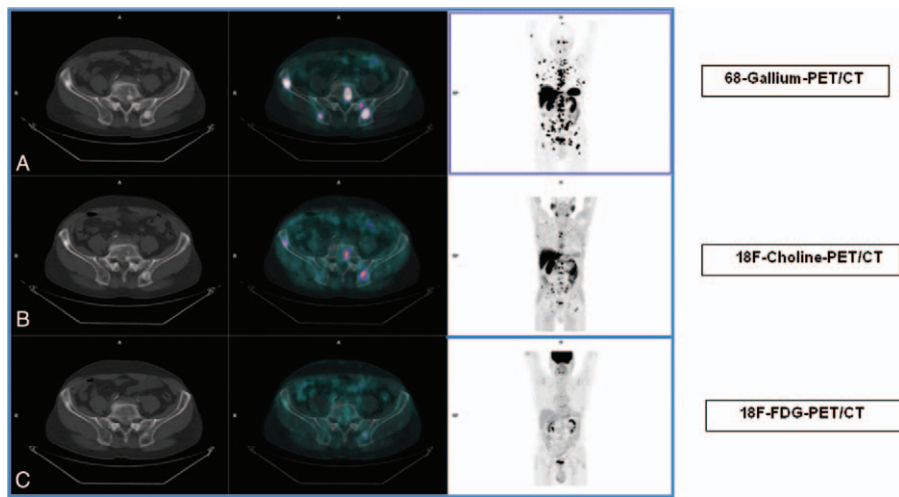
A 71-year-old male treated with temozolomide for advanced NET of unknown origin with widespread bone disease, liver metastases, and increased serum PSA (8.0ng/mL). (A) ⁶⁸Ga-DOTATOC PET/CT axial, sagittal, and maximum intensity projection views show widespread intensely ⁶⁸Ga-DOTATOC-avid skeletal disease (SUVmax at the left iliac crest: 83); and liver involvement (SUVmax: 47.6). (B) Corresponding ¹⁸F-FDG PET/CT axial and sagittal views showing very mild-to-mild tracer uptake in a few pelvic and vertebral bone lesions (SUVmax at the left iliac crest: 4.1). (C) Corresponding ¹⁸F-FCH PET images document mild-to-moderate ¹⁸F-FCH uptake in a number of axial and appendicular skeletal lesions (SUVmax at the left iliac crest: 7.5). ¹⁸F-FCH coregistered low-dose CT shows the sclerotic pattern of some prominent lumbosacral and pelvic bone lesions, all positive to ⁶⁸Ga-DOTATOC. CT=computed tomography, ¹⁸F=¹⁸fluoro, FCH=fluorochole, ⁶⁸Ga=⁶⁸gallium, NET=neuroendocrine tumor, PET=positron emission tomography, PSA=prostate specific antigen, SUV=standardized uptake value.
